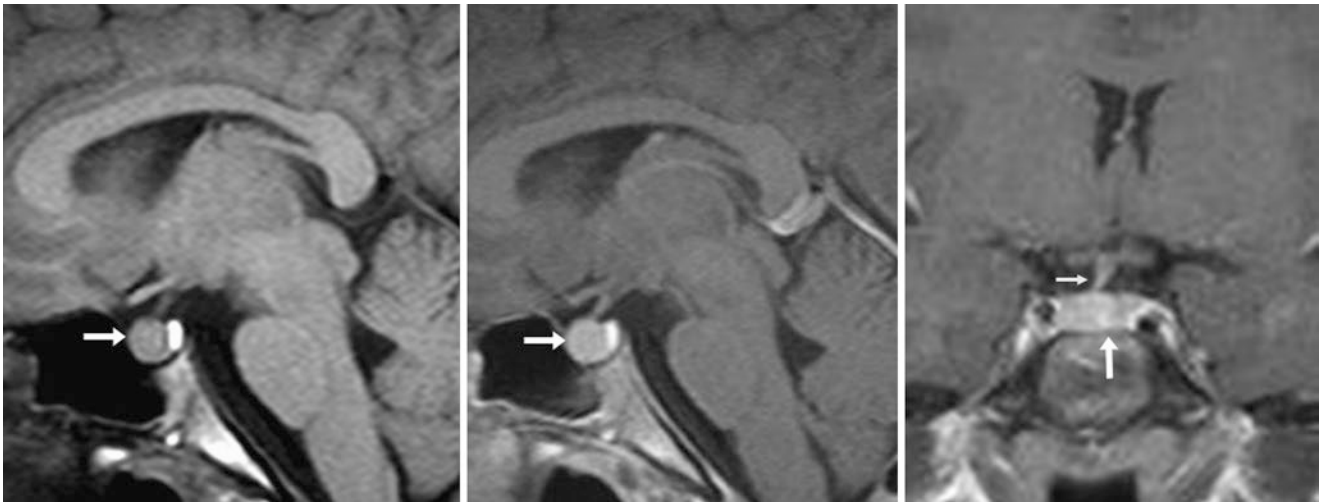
The patient was a 12-year-old pubescent female with headaches but an otherwise normal MRI. The borderline enlarged pituitary (arrows) on a 1.5 T MRI measured 9.3 mm in height on sagittal T1WI
